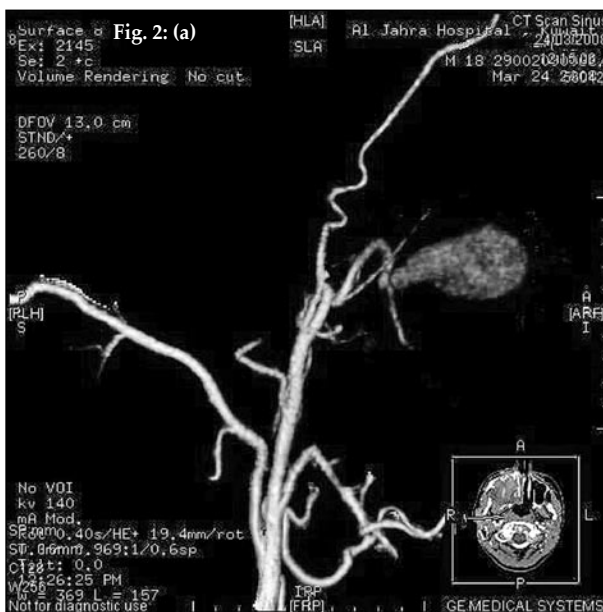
a, b: CT angiography of the right carotid artery confirming the vascular nature of the tumor; it showed the presence of aneurysm of the IMA
